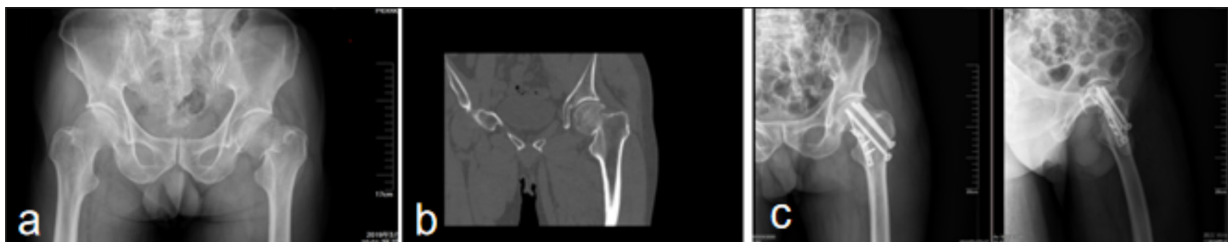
Treatment on a patient with a left femoral neck fracture caused by trauma. Pauwels type III was determined as follows: (a) CT confirmed that the femoral neck fracture belonged to Pauwels III; (b) Postoperative reexamination; (c) 3 months after the operation, fracture healing, and internal fixation were stable.
